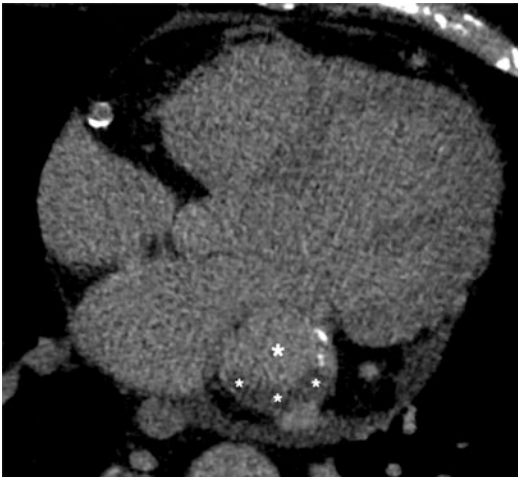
Cardiac CT demonstrating thrombus in a Kawasaki aneurysm. Same patient as Fig. 8 but at a different place in the circumflex artery. The images have been acquired in a late venous phase at 6 min after contrast, although it is unusual to have to wait this long. The aneurysm (larger asterisk) is uniformly enhanced except for a posterior low attenuation crescentic rim (smaller asterisks) which represents chronic mural thrombus
